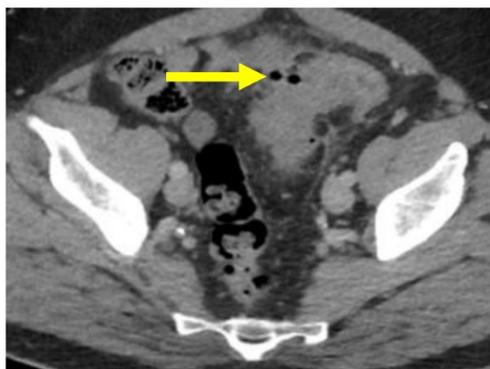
Microperforation. Axial CT image through the pelvis with IV contrast. There is a small amount of extraluminal air (yellow arrow) along the medial wall of the sigmoid colon, without evidence for abscess. There is adjacent inflammation related to acute diverticulitis.
